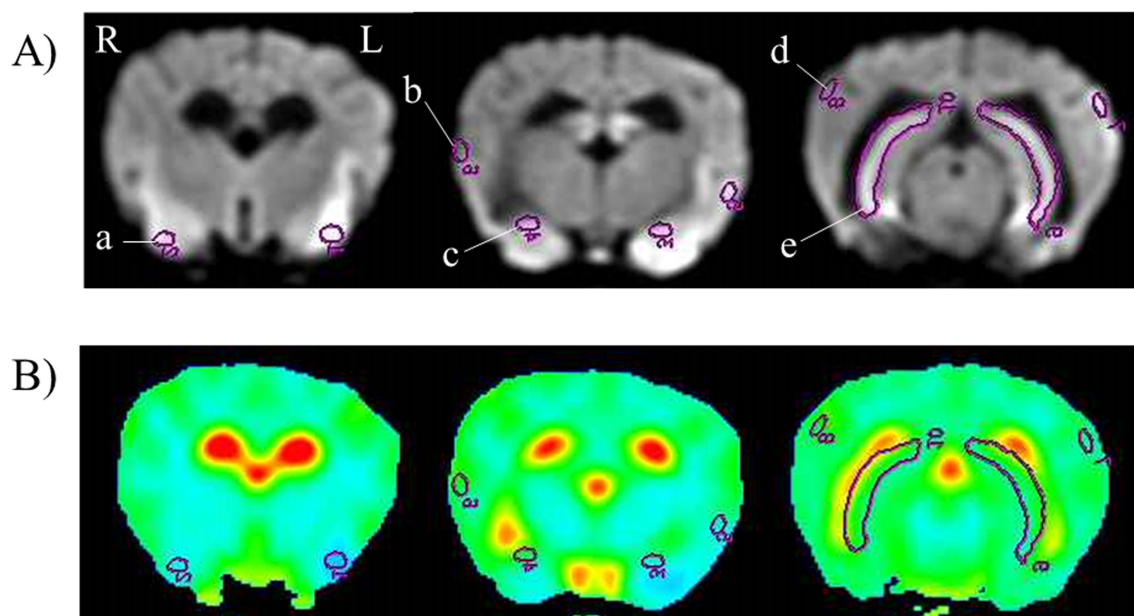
The region of interest (ROI) locations for the apparent diffusion coefficient (ADC) values. A) These images were DWI. The ROI was set on the piriform lobe (a), gyrus sylvius (b), amygdala (c), gyrus ectosylvius medialis (d), and hippocampus (e). DWI, diffusion-weighted imaging; L, left side; R, right side. B) These images were ADC maps. The ADC values were observed by these images.
